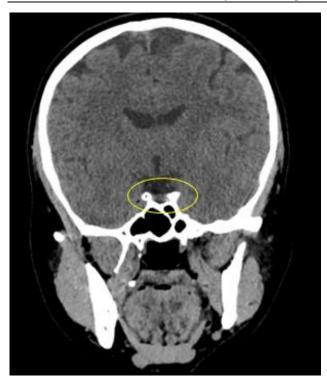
Computed tomography showing a pituitary micro-nodule in a patient with early-onset hypopituitarism - Frontal plan
